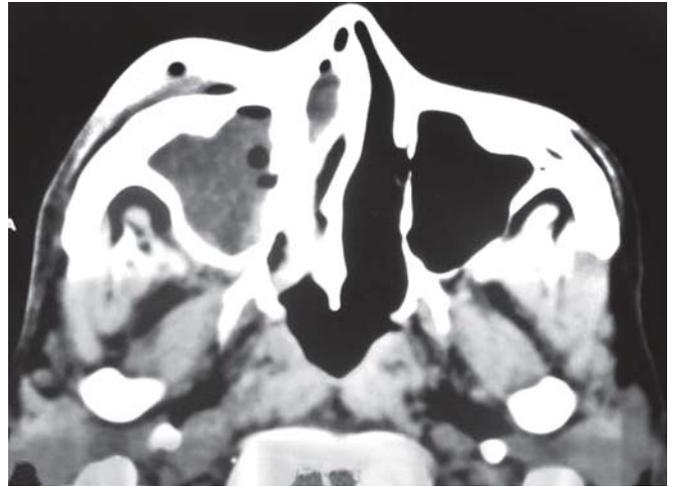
Preoperative CT scan showing hypodense area in the right maxillary sinus and nasal cavity
